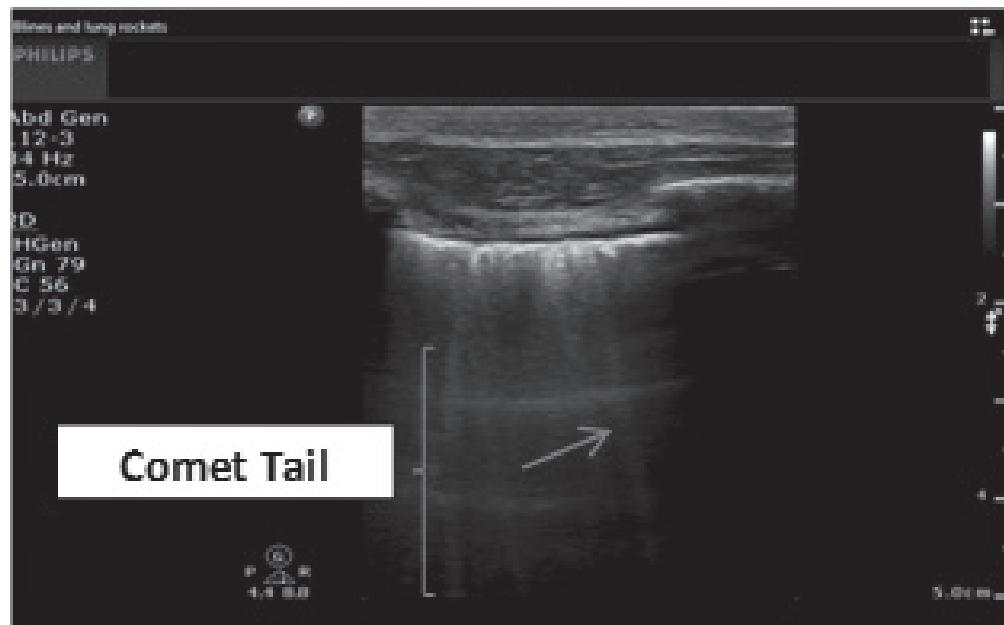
Image courtesy of Daniel Haase, MD, RDCS, RDMS, Assistant Professor of Emergency Medicine, Program in Trauma/Surgical Critical Care, Shock Trauma Critical Care Ultrasonography, University of Maryland School of Medicine and R Adams Cowley Shock Trauma Center.
